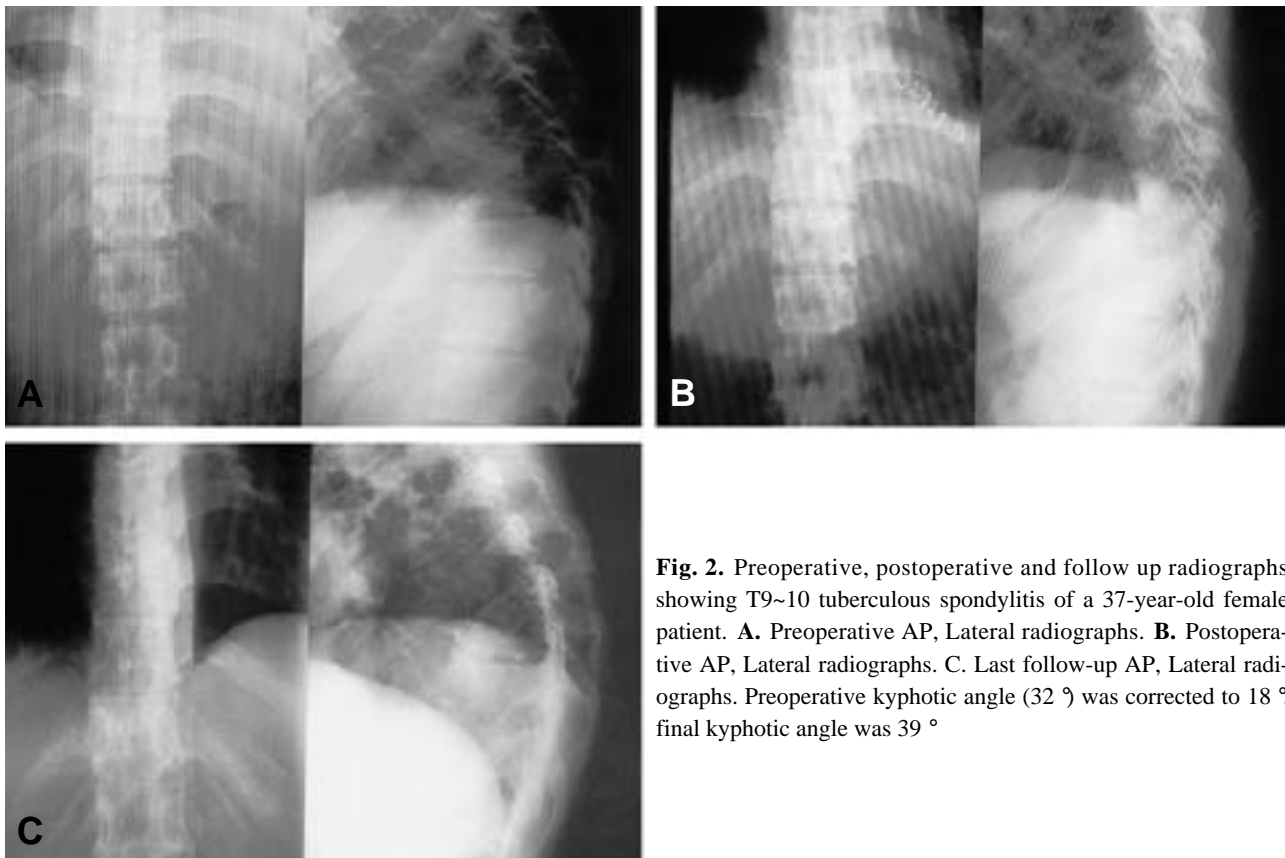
Preoperative, postoperative and follow up radiographs showing T9~10 tuberculous spondylitis of a 37-year-old female patient. A. Preoperative AP, Lateral radiographs. B. Postoperative AP, Lateral radiographs. C. Last follow-up AP, Lateral radiographs. Preoperative kyphotic angle (32 °) was corrected to 18 °. final kyphotic angle was 39 °.
